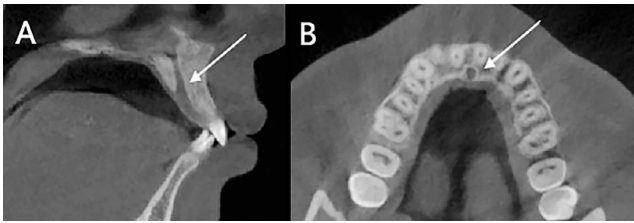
Sagittal (A) and axial (B) image of the IC (arrow) by CBCT.
